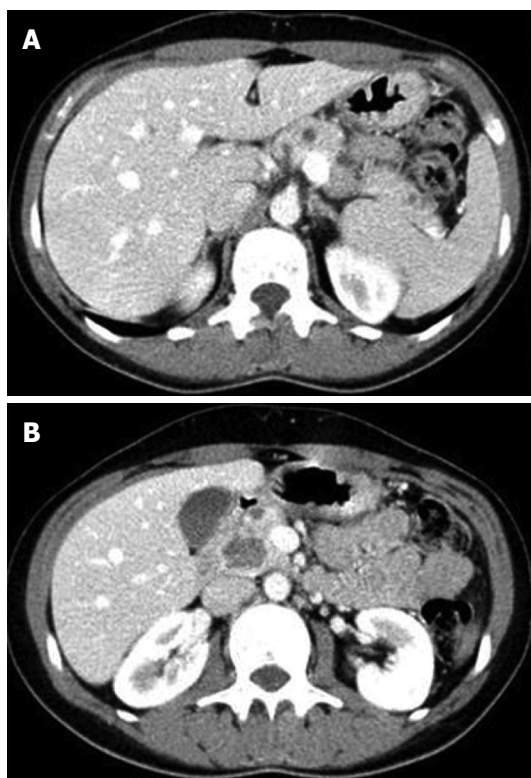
Computed tomography abdominal scan. A: Small cystic lesions dispersed throughout the pancreas; B: The largest lesion.
